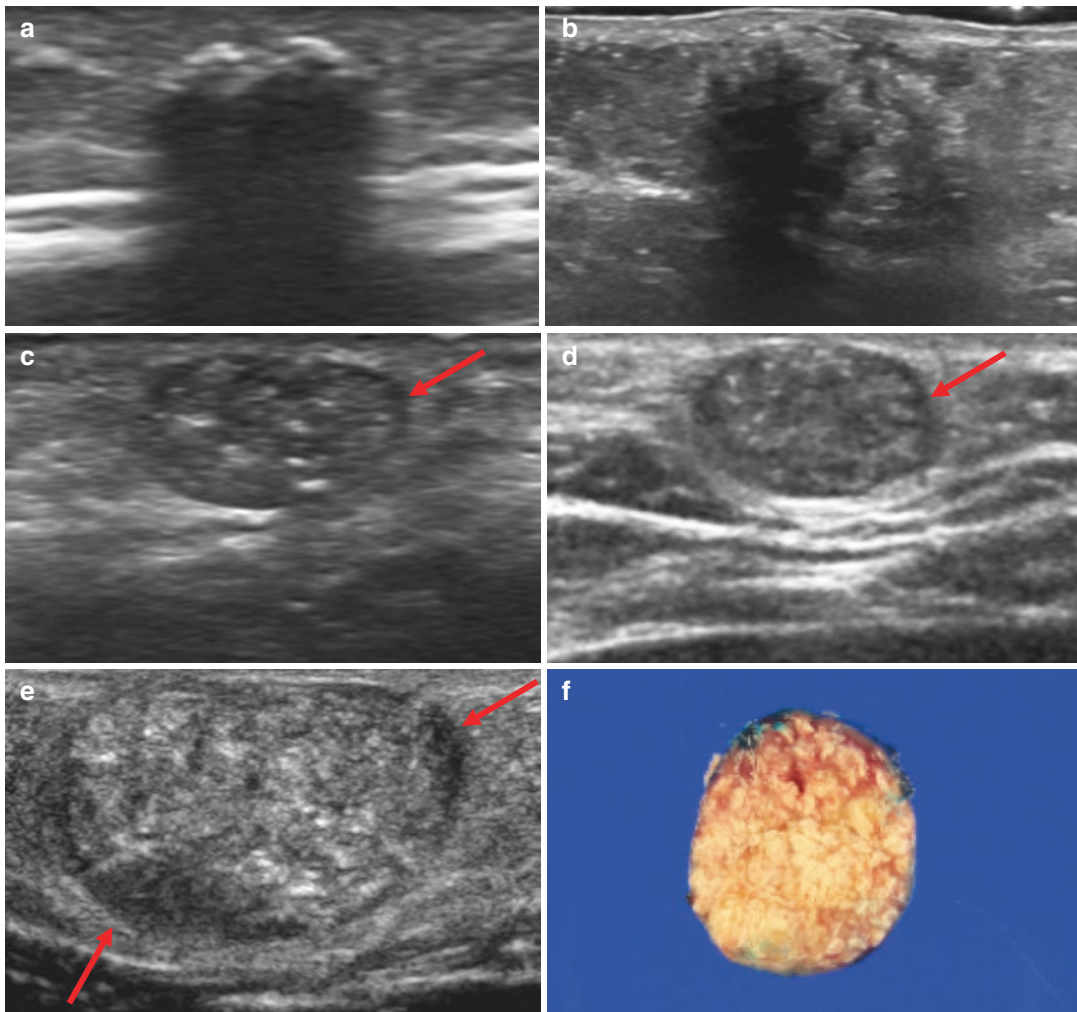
Pilomatricoma. Variable sonographic appearances of pilomatricoma. Completely calcified pilomatricoma with posterior acoustic shadowing artifact (a). Irregular hyperechoic lesion with an obscured margin due to posterior acoustic shadowing (b). Well-defined iso- to hyperechoic masses with variable internal echogenic foci
